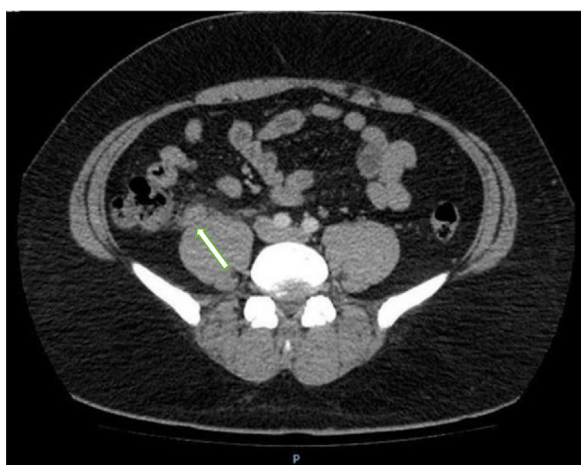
CT Abdomen Axial view: Acute appendicitis unable to view diverticulum of appendix.
